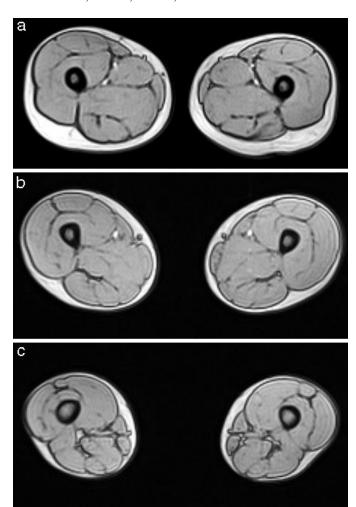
Axial magnetic resonance imaging scans at the (a) proximal, (b) middle, and (c) distal levels.
